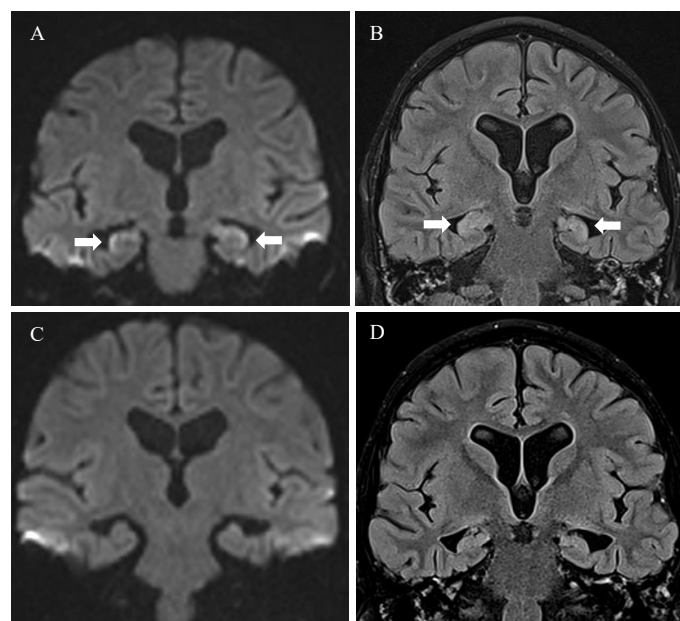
Acute limbic encephalitis after allogeneic stem cell transplantation. A and B: DWI (A) and FLAIR (B) at presentation (day +28): Limbic encephalitis-like manifestations on MRI images. (A) Coronal DWI-MRI image shows bilateral diffusion restriction of the hippocampus with hypersignal and swelling on FLAIR (B). C and D: DWI (C) and FLAIR (D) after 5 weeks (day +62) show complete imaging resolution
